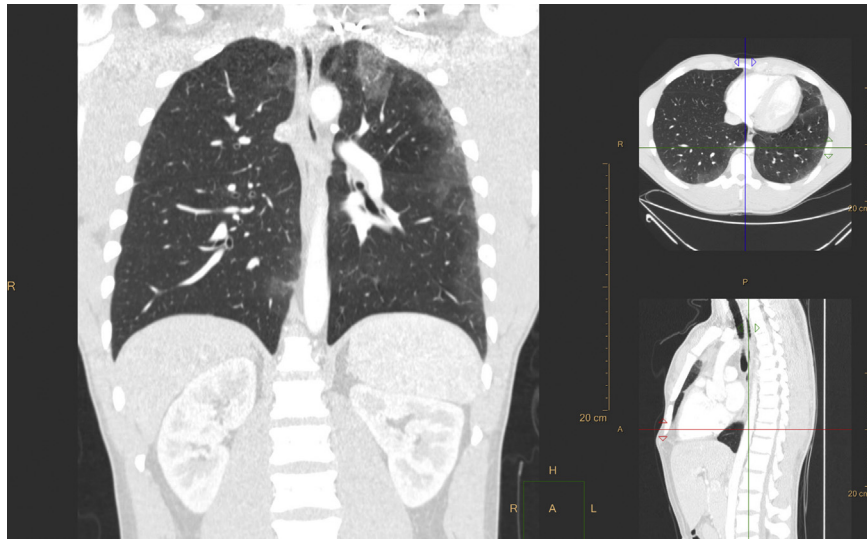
HRCT showed patchy areas with ground glass opacities located primarily in the periphery of the lungs.
